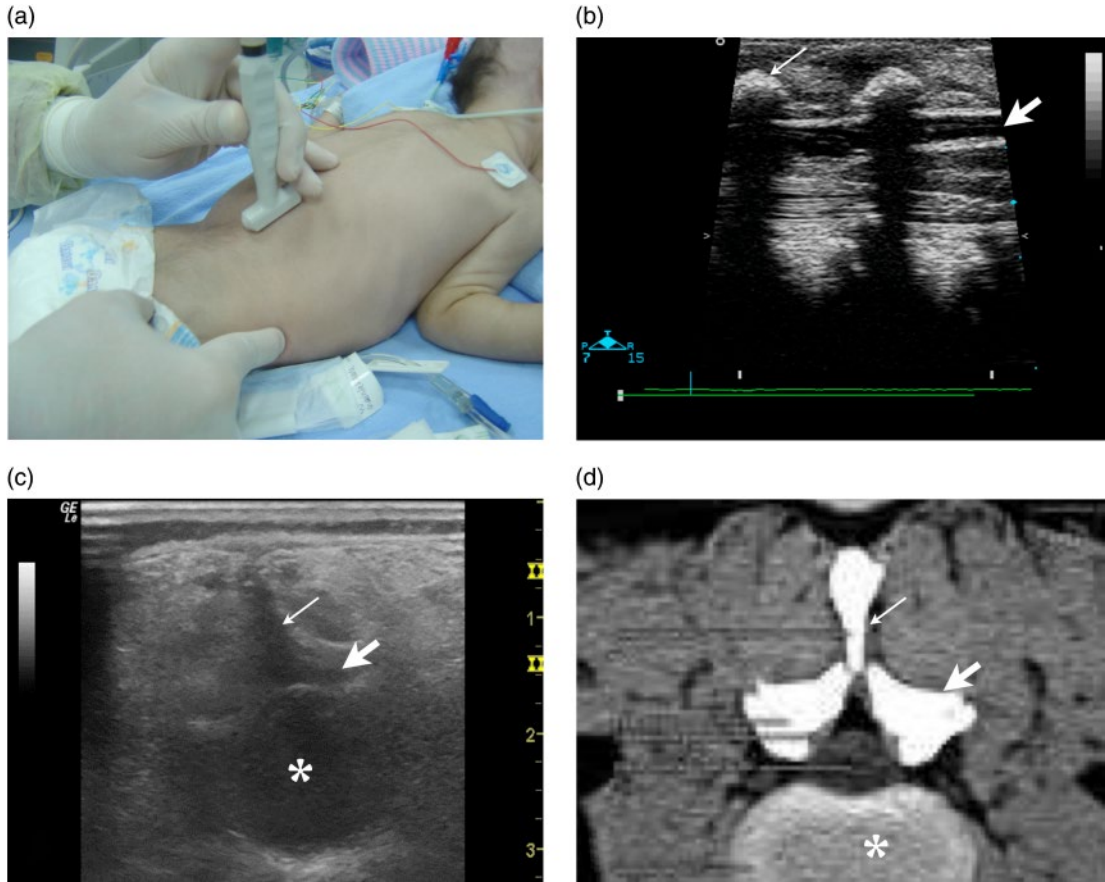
Ultrasound-guided lumbar puncture. (a) Patient and probe position. (b) Image of longitudinal view of lumbar spine and spinal canal with fluid (thick arrow). Spinous process (thin arrow). (c) Sonographic image and (d) CT image of vertebral body anatomy. Spinous process (thin arrows), transverse process (thick arrows). Vertebral body (stars).
